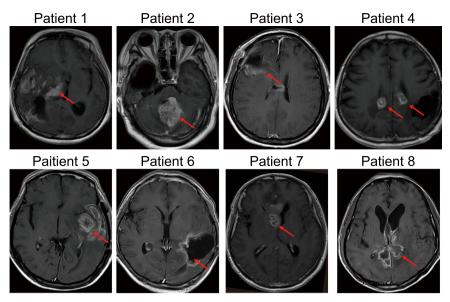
MRI determination of the tumour site and the location of the tumour communication with the ventricular system (red arrow). Patient 1: right lateral ventricle; Patient 2: fourth ventricle; Patient 3: right lateral ventricle; Patient 4: bilateral ventricle; Patient 5: left lateral ventricle; Patient 6: left lateral ventricle; Patient 7: right lateral ventricle and third ventricle; Patient 8: bilateral ventricle.
